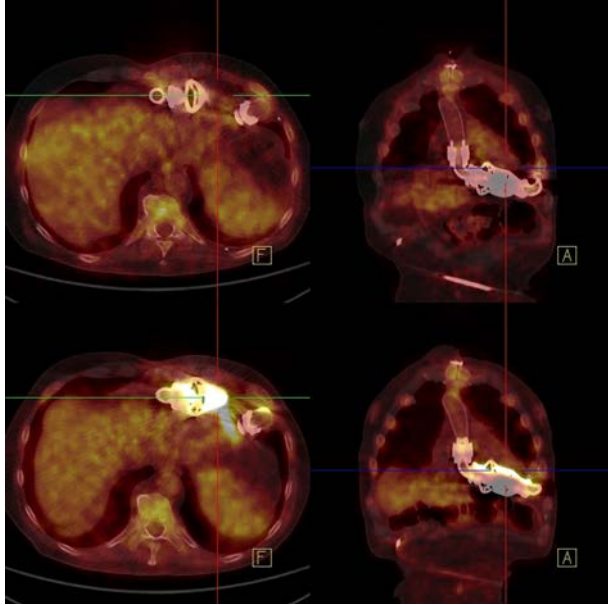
Patients with infected ventricular assist devices. ^{18}F -FDG PET-CT baseline: high accumulation of ^{18}F -FDG in the pocket containing the ventricular assist device (bottom row). After antibiotic therapy, a follow-up ^{18}F -FDG PET-CT one year later shows no further accumulation of ^{18}F -FDG in the pocket containing the ventricular assist device (top row). (Courtesy of D. Sobic Saranovic, Clinical Center of Serbia.)
